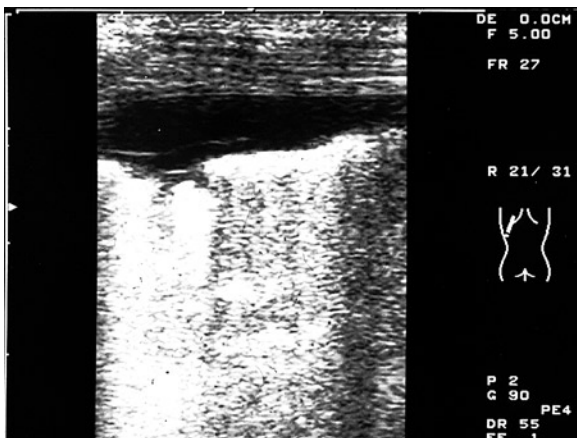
Circumscribed small pleural effusion on the left side posteriorly indicating a pleuritis without pleural thickening. On the day before, the patient suffered from respiration-dependent pain, which was already declining at the time of the ultrasound examination. General malaise. One intercostal space higher absent pleural effusion (right side of the image)
